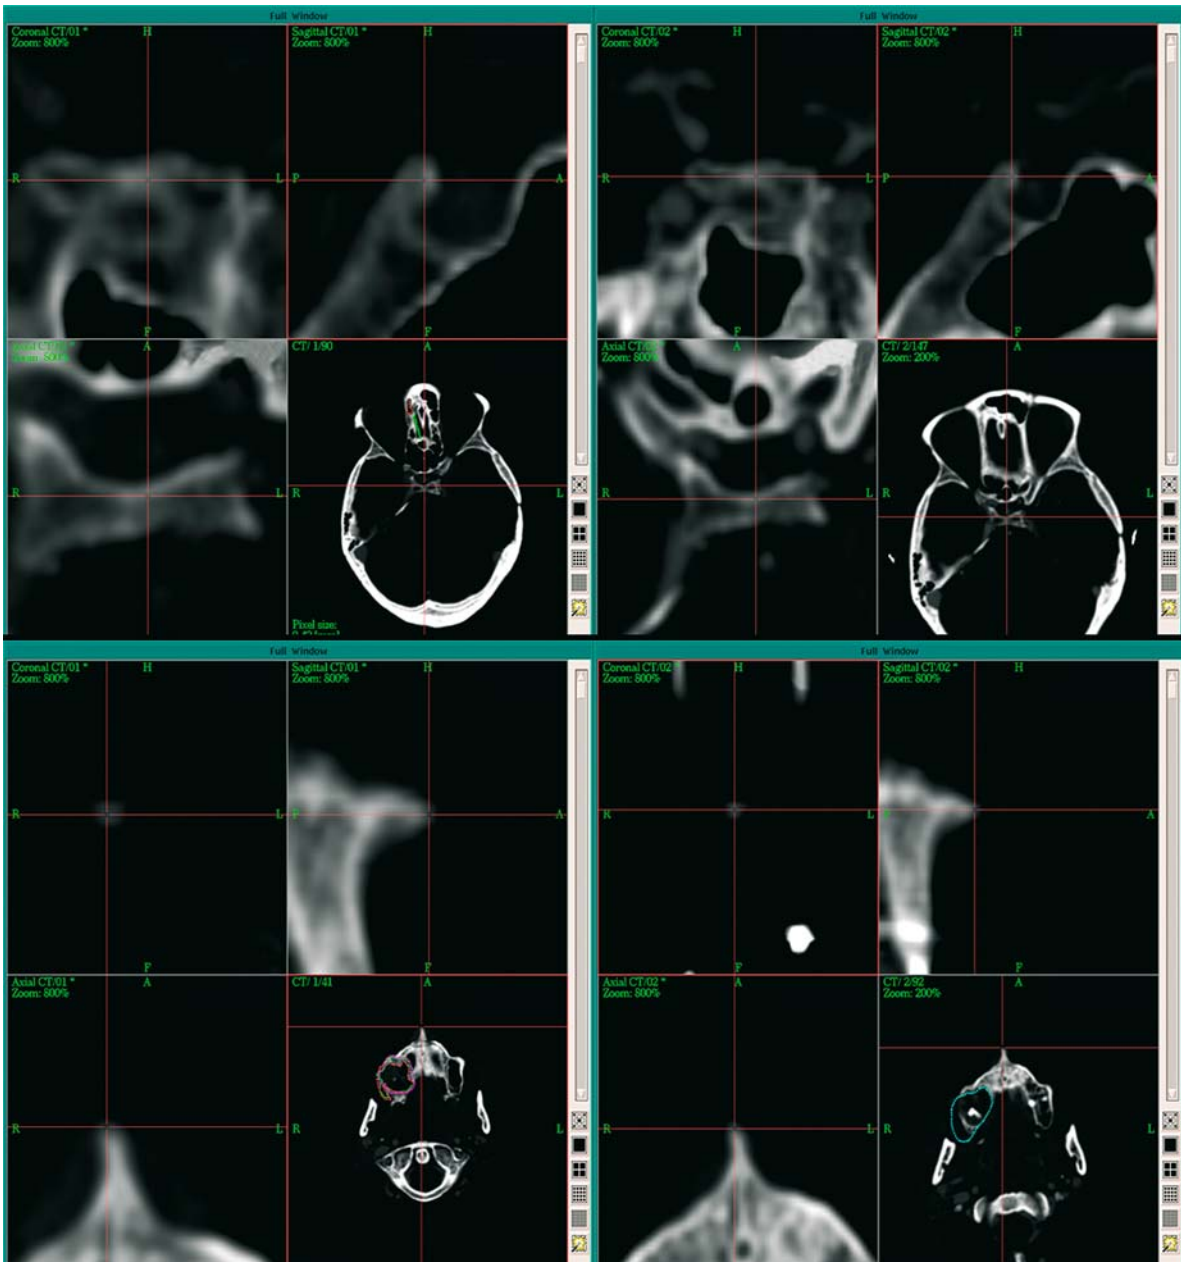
Image fusion of two CT data sets based on the use of anatomical landmarks. The sella turcica (*above*) and the anterior nasal spine (*below*) are reproducible landmarks that are
